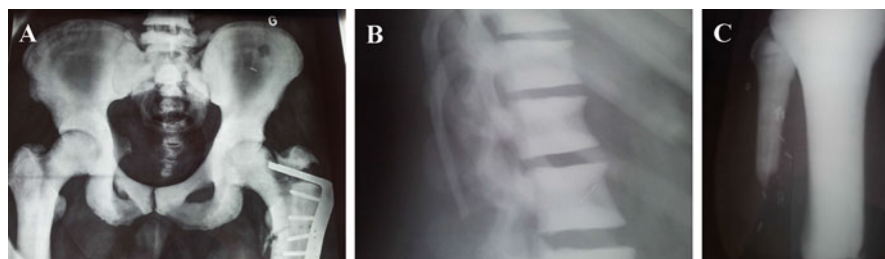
Typical ADO II X-ray features. (a) A sclerotic vertebral plate, also called “sandwich vertebra.” (b) Endobone observed on the iliac bone, also called “bone in bone.” (c) A typical Erlenmeyer femoral diaphysis
